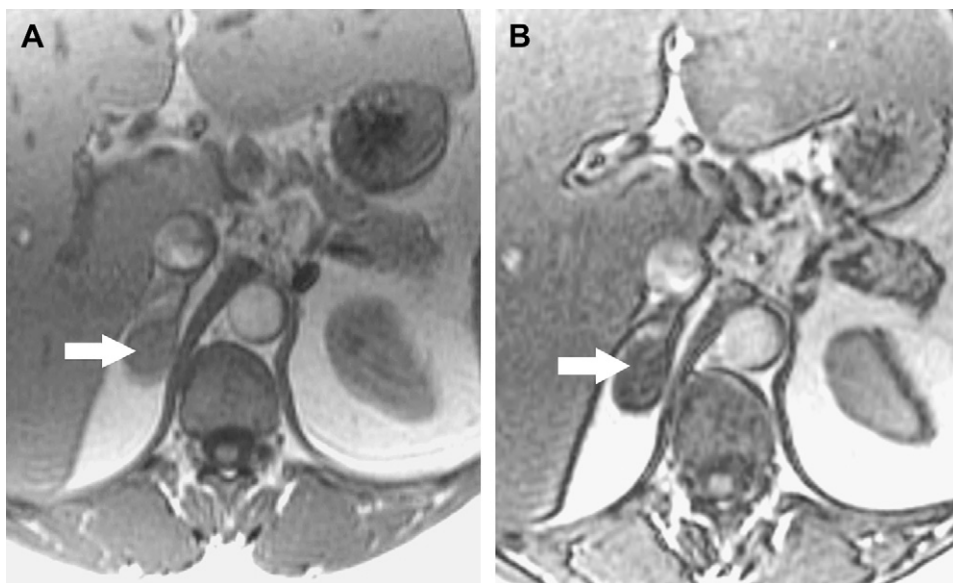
CSI adenoma. MR image showing left adrenal masses (arrows) showing signal intensity drop between IP (A) and OOP (B) images consistent with adenoma. Notice how the liver also drops in signal on OOP imaging due to fatty liver, a behavior that makes it unsuitable as an internal standard reference organ.
